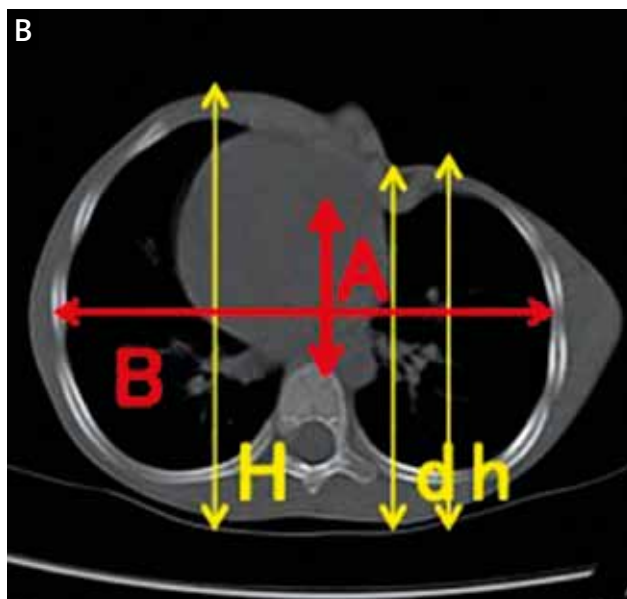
A) Preoperative findings. B) Preoperative axial CT Measured values (cm): A = 4.61, B = 15.88, d = 10.88, H = 12.79, h = 10.95
